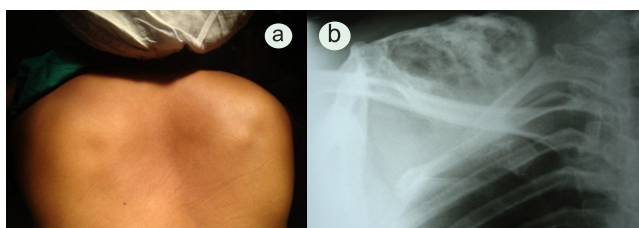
a- Photograph of the patient shows prominent medial border of right scapula (Pseudo-winging). b- AP scapular radiograph showing osteochondroma arising from scapula.
